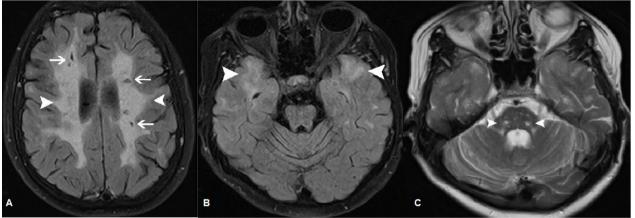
Brain MRI. Axial FLAIR images show symmetrical confluent hyperintense signal changes in the periventricular and the subcortical white matter and the anterior temporal lobes (arrowheads). Note that the U-fibers are spared. A. Lacunar infarctions (arrows). C. Axial T2-weighted image shows lacunar infarctions in the brainstem (arrowheads).
